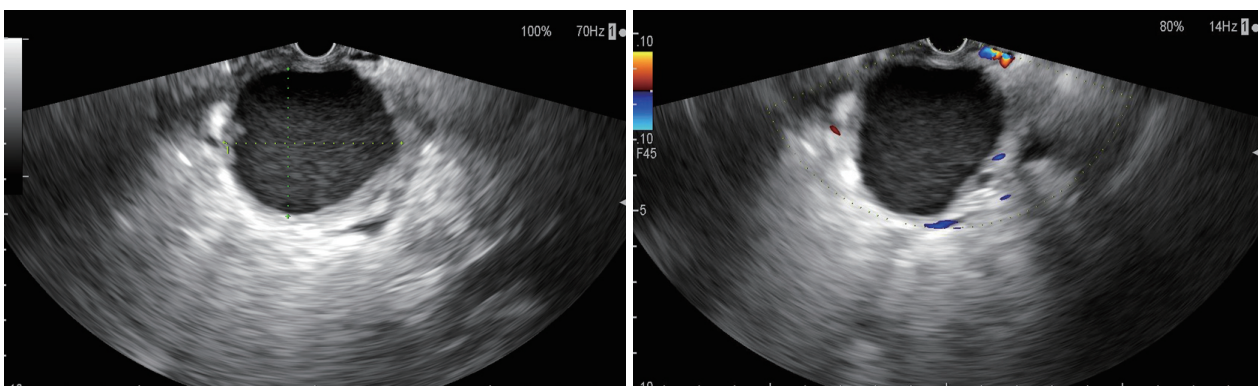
Endoscopic ultrasound image. These revealed a homogeneous pseudocyst mass, and the cyst wall had a thickness of approximately 10 mm. Good adhesion was noted between the cyst wall and the posterior gastric wall.
